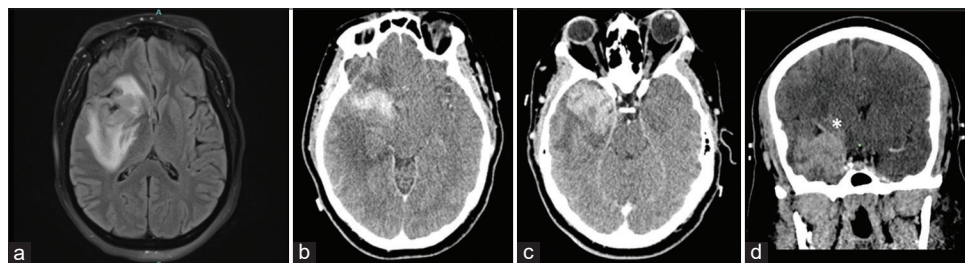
(a) FLAIR magnetic resonance imaging showing right temporal and insular lesion with right to left mass effect and surrounding edema. (b and c) CT with contrast demonstrating irregular enhancement of a large right temporal and insular lesion. (d) A coronal view of the preoperative CT with contrast, with an emphasis on the Sylvian fissure and middle cerebral artery (MCA) being pushed upward (asterisk).
